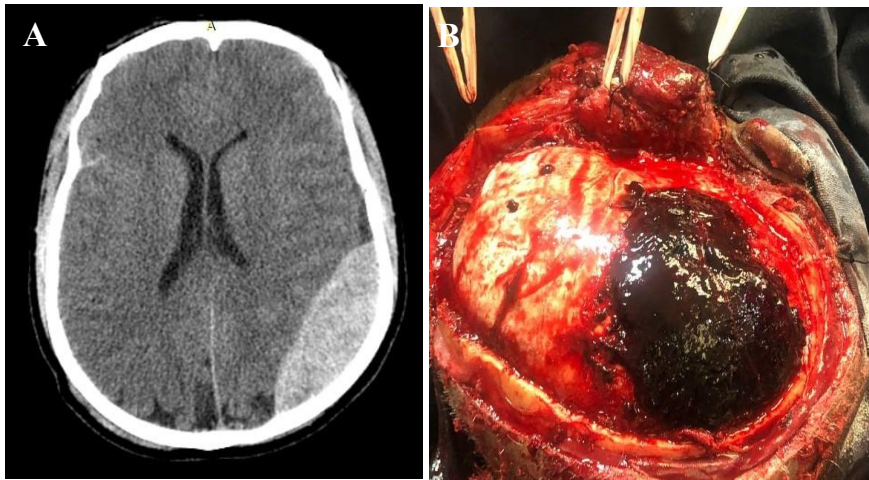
Management of epidural hematoma. (A) A non-contrast CT showing a left-sided epidural hematoma. (B) A dark clotted epidural hematoma visualized right after craniotomy. Photos: Tsegazeab Laeke.
